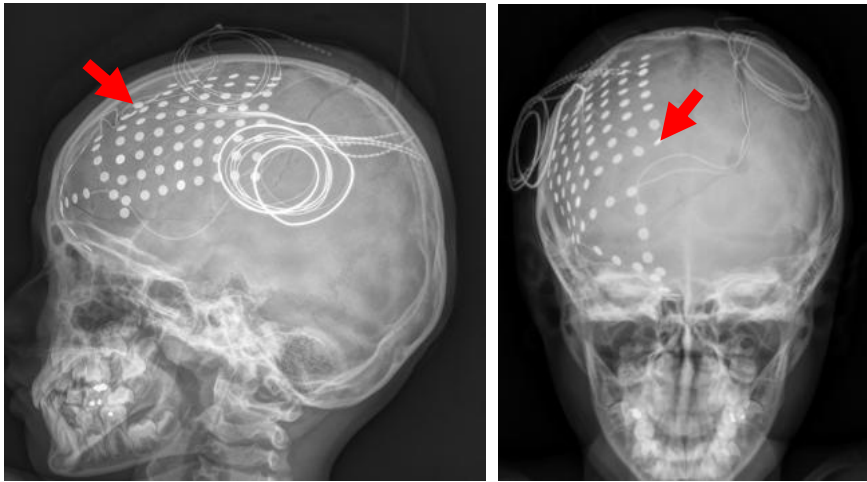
X-ray radiography of the first patient with implanted ECoG electrodes. The arrows mark the same electrode.
